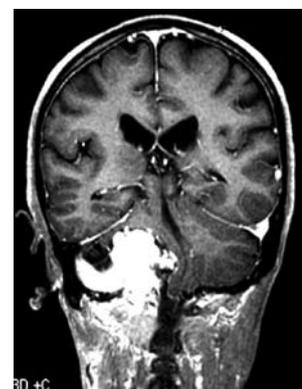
Coronal cut, post contrast T1 weighted MRI.
